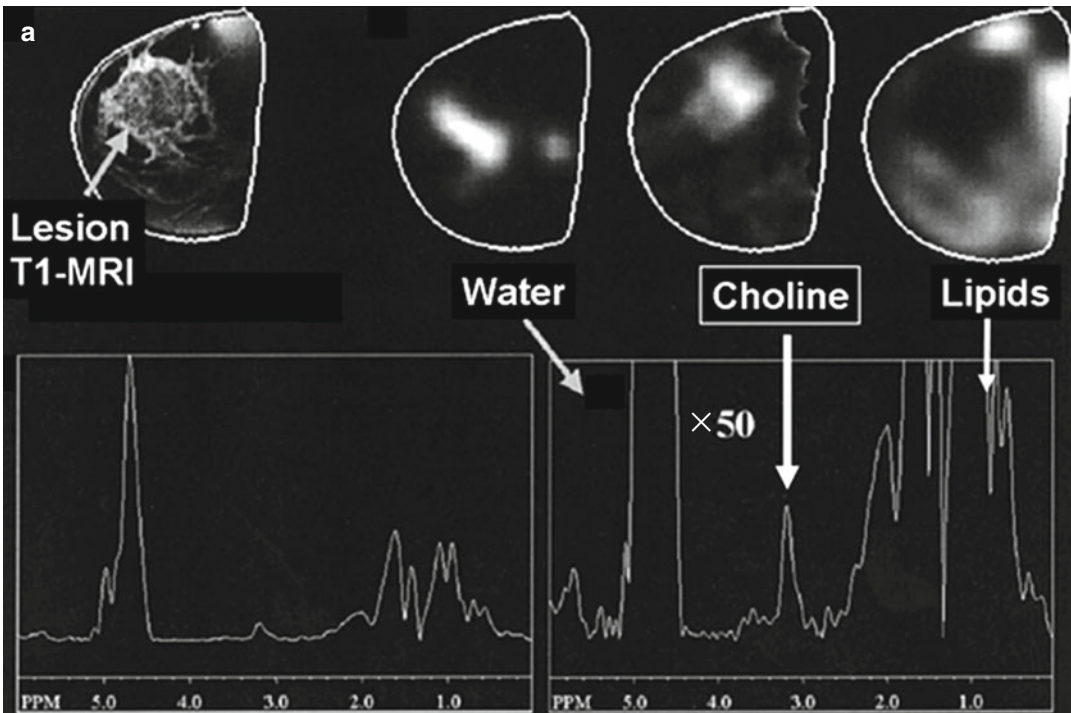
Anatomical MRI and metabolic ¹H-MRS/MRSI on patients with breast cancer. (a) A patient with infiltrating ductal carcinoma of the breast with spatial colocalization of malignant margins by contrast-enhanced T1-weighted MRI and tCho-¹H-MRSI (Adapted from
